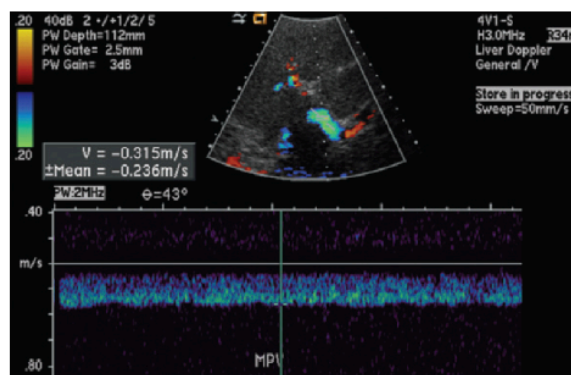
Hepatofugal portal venous flow. Spectral Doppler US image shows retrograde (hepatofugal) flow in the main portal vein, a finding that appears blue on the color Doppler US image and is displayed below the baseline on the spectral waveform. Hepatofugal flow is due to severe portal hypertension from any cause.
